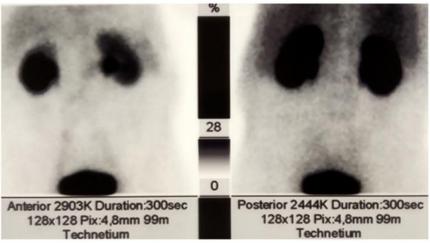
Abdomen and pelvis scintigraphy with radiolabeled erythrocytes: no signs of bleeding.
